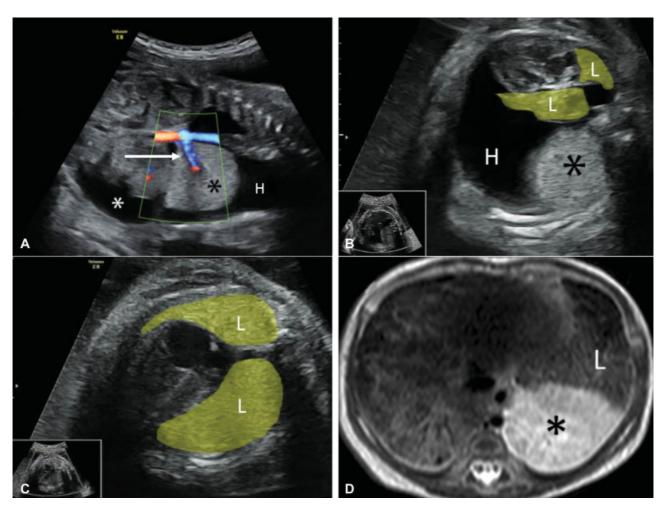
(A) Prenatal ultrasound scan demonstrates extralobar bronchopulmonary sequestration (black.) with feeding vessel (white arrow), hydrothorax (H), and ascites (white.) before treatment. (B) Collapse of lung tissue and mediastinal shift are visible in transverse thoracic image. (C) Expanded lungs (L) are detected after treatment. (D) Magnetic resonance imaging at 3 weeks of age confirmed the presence of bronchopulmonary segestration (black .).
